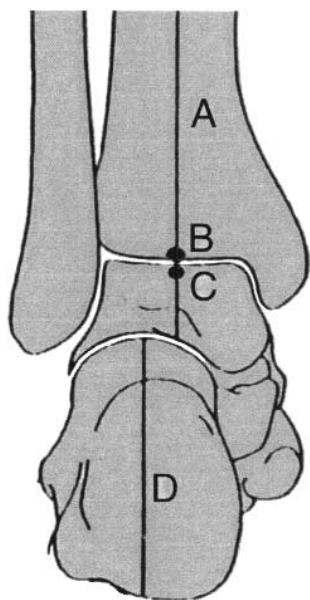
The angles measured on an axial or rearfoot alignment weightbearing radiograph of the foot, ankle, and leg include the angle between the mid-diaphyseal line of the tibia (A) and the calcaneal bisection line (D) (normal = 0°–2° valgus). As on the anteroposterior radiograph of the ankle, the center of the talar dome (C), the mid-diaphyseal line of the tibia (A), and the center of the tibial plafond (B) should all coincide.
